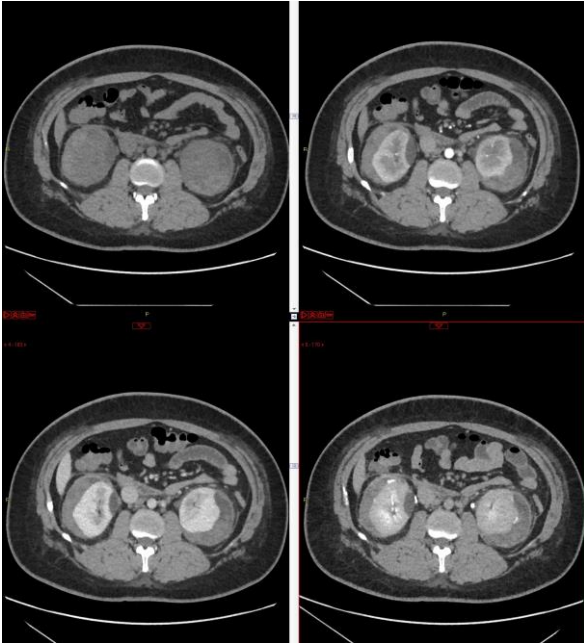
CT before and after contrast agent administration, on axial planes. On the basal phase (upper figure on the left) spontaneous hyper-attenuation in perirenal subcapsular space could be noted. On late excretory phase (lower figure on the right) multiple bilateral contrast agent blushes into the hematomas may be noted, diagnosed as multiple bilateral active bleedings.
